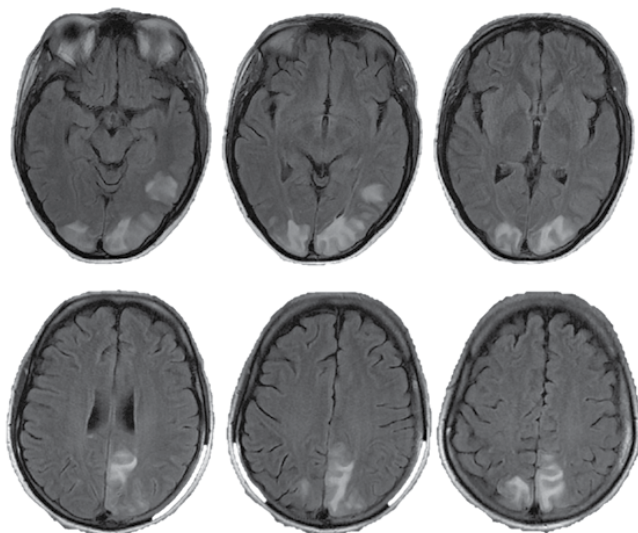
Magnetic resonance imaging of brain T2 FLAIR.
